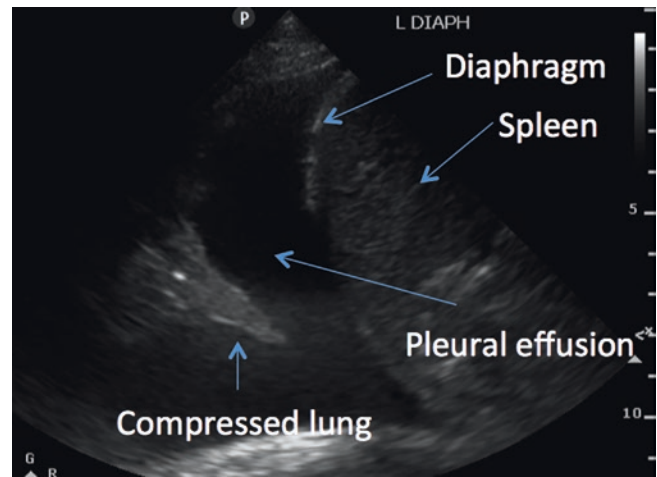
Lung ultrasound for detection of pleural effusion. Pleural effusion can be rapidly diagnosed by using bedside lung ultrasound and small effusions can be localized for aspiration. Pleural effusion is best demonstrated in the dependent areas with the probe placed in the intercostal space with the indicator of the probe pointing cranially. The effusion appears as echo free or hypoechoic (i.e., dark) space and is delineated by the chest wall and the diaphragm. The fluid acts as an acoustic window and the underlying lung can also be visualized. In this case compressive atelectasis is seen. In compressive atelectasis, the underlying lung is not consolidated and therefore will change in shape with respiration demonstrating the “jellyfish sign.” See also Video 37.3
